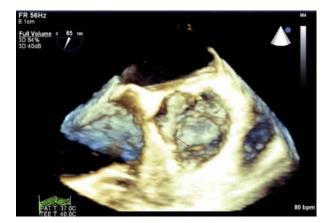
Three-dimensional transesophageal echocardiography shows continued presence of the opacity (*arrow*) after weaning from cardiopulmonary bypass.
